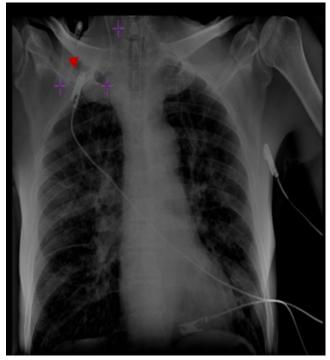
Chest radiograph showing a central line inserted in the right internal jugular vein, catheter located at persistent right subclavian vein (arrow).
